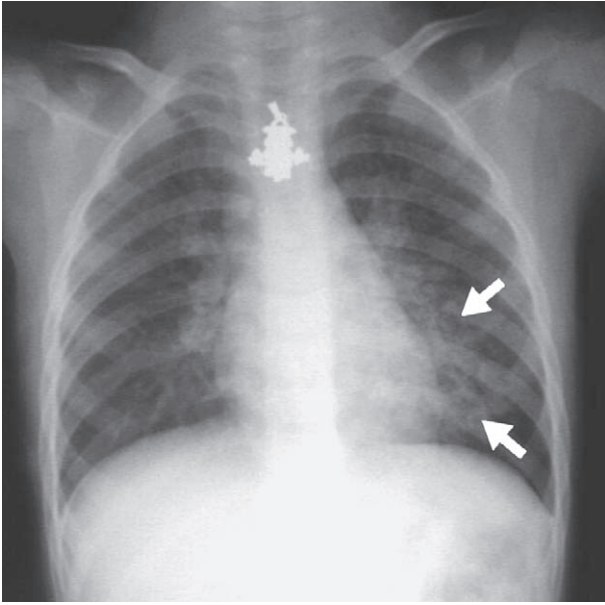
A 6 year-old boy presented with a 3 day history of high fever and productive cough. Frontal chest radiograph shows reticulonodular opacities (arrows) in the left lower lung zone. Bilateral peribronchial and perivascular interstitial infiltrates also are noted.
